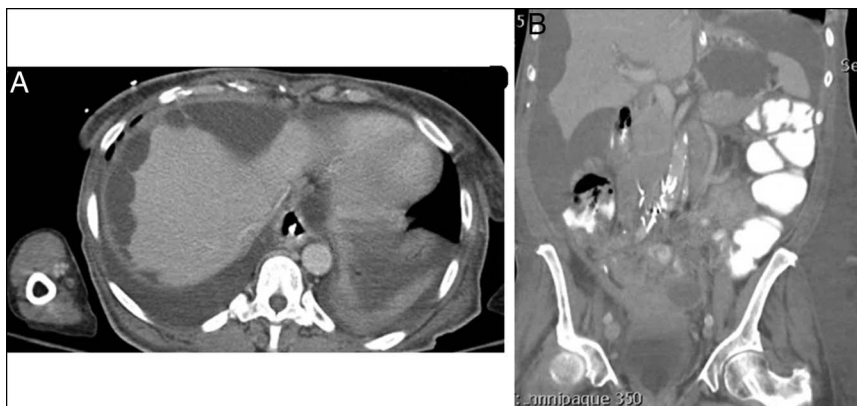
Contrast abdominal computed tomography images, (A) axial view, (B) coronal view, revealing classic “scalloping” of the liver in the setting of gelatinous ascites.
